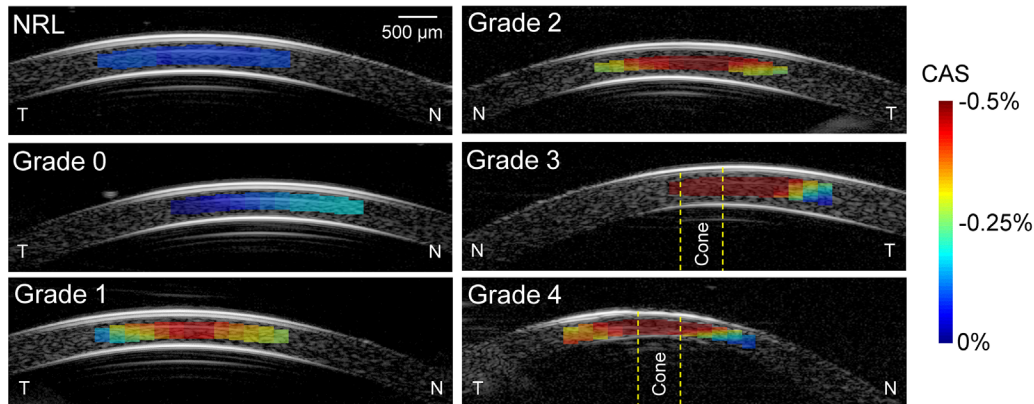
Representative CAS spatial maps for one normal subject (NRL) and a patient from each grade of keratoconus corneas. The cone center in grades 3 and 4 keratoconus is defined as the 500 μm region of stroma centered at the thinnest point of the cornea in the ultrasound B-mode image. CAS in keratoconus corneas was in general higher, especially in the cone center, and more spatially variable.
